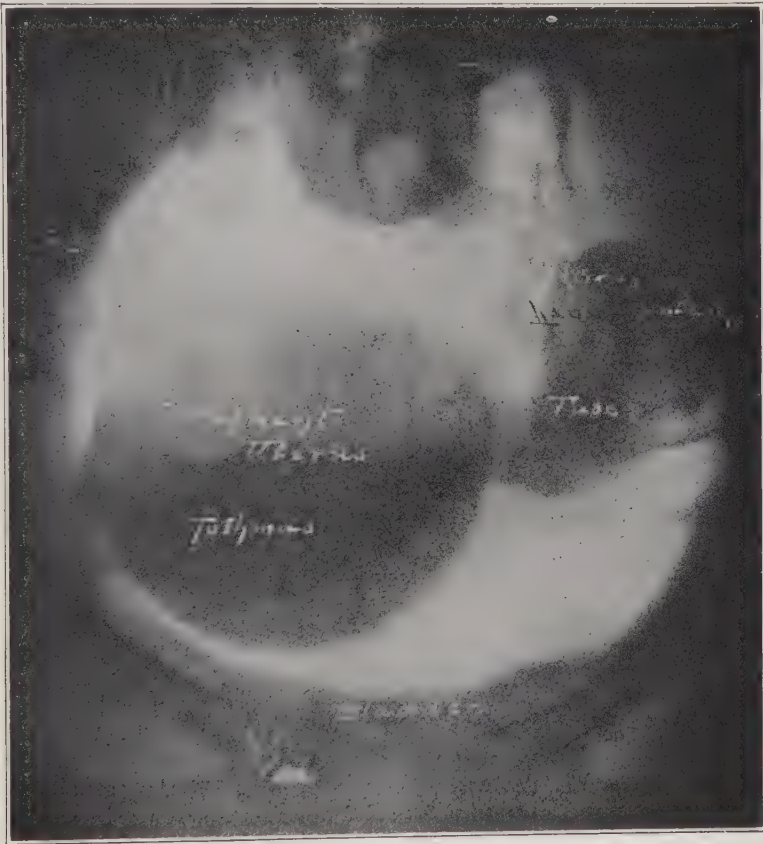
Early pregnancy. Uterus in right side of pelvis. (Peterson—*Am. Jour. Roentgenology*.)
